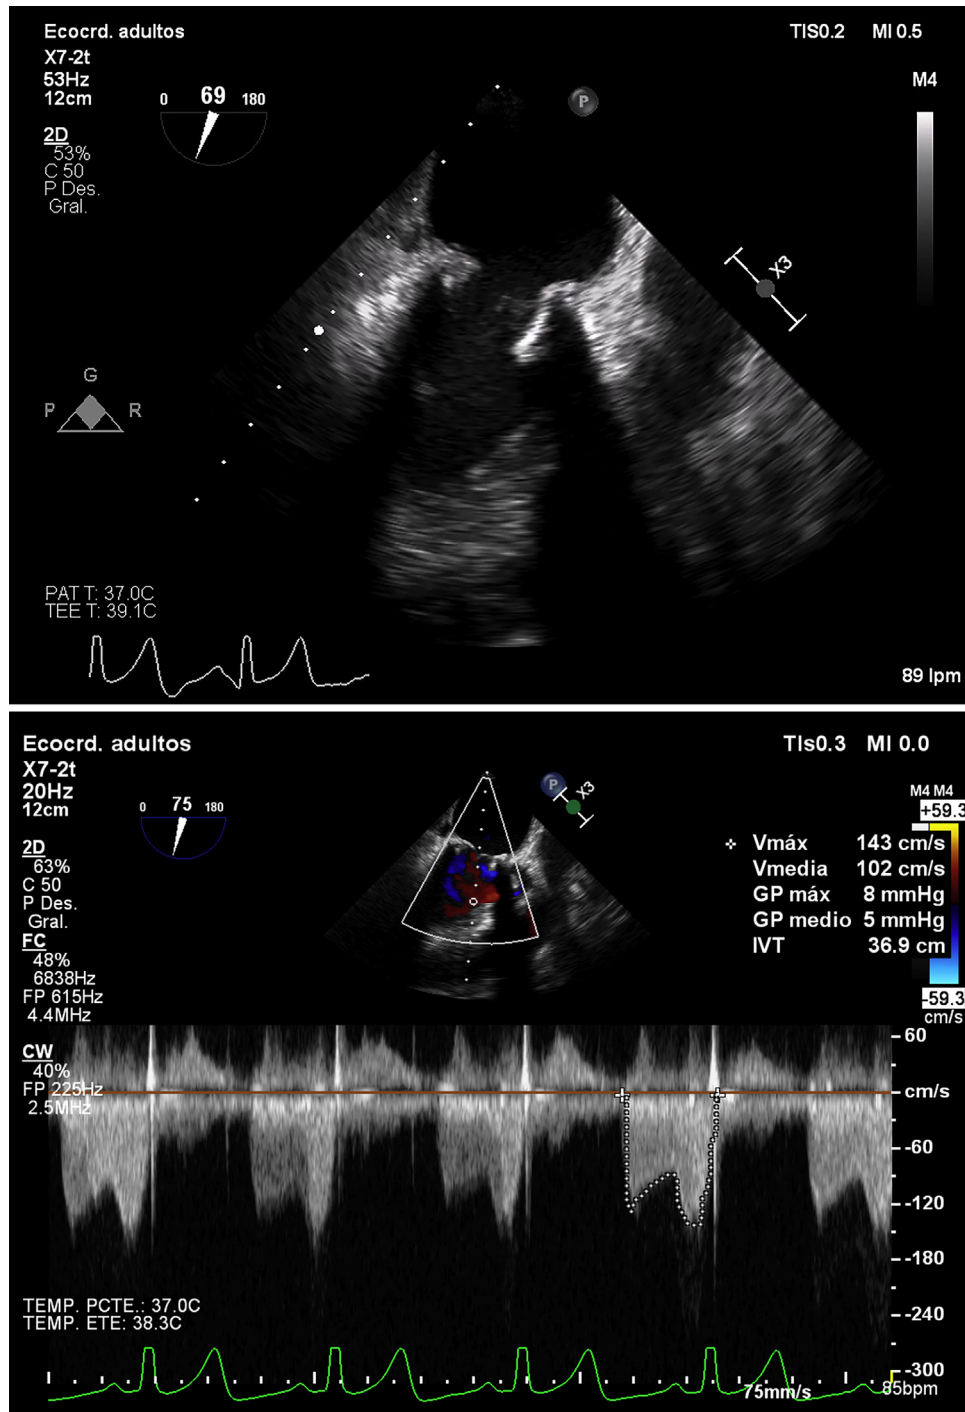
Transesophageal echocardiography (2-dimensional) 15 days later: mesoesophageal 2-chamber view showing resolution of prosthetic stenosis with thin leaflets and normal valve opening, only mild restriction of anterior mitral leaflet persisting with complete telediastolic opening (transmittal gradient of 5 mm Hg).
